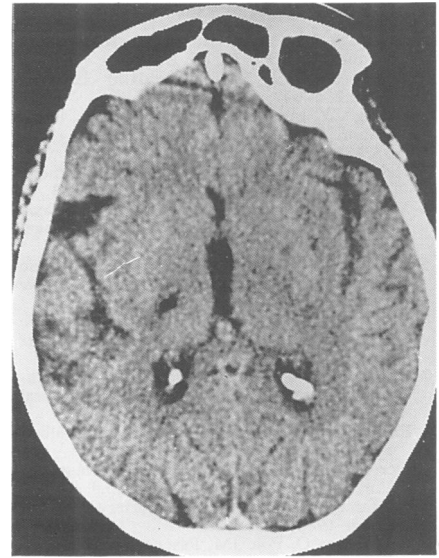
Figure CT scan taken at 8 months of onset showing lacunar infarct in the right posterior limb of the internal capsule.
